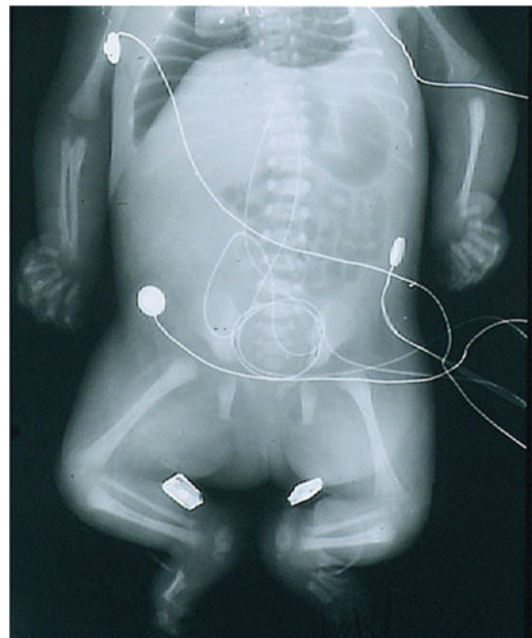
Radiograph showed gracile ribs, thin long bones, flexion contractures at the elbows and knees, and clenched hands
